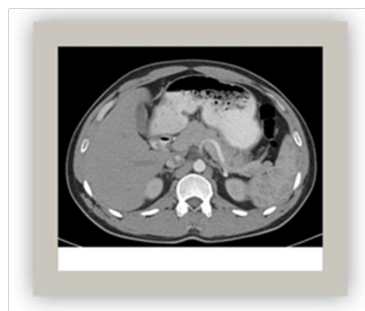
Contrasty abdominal CT horizontal section.
